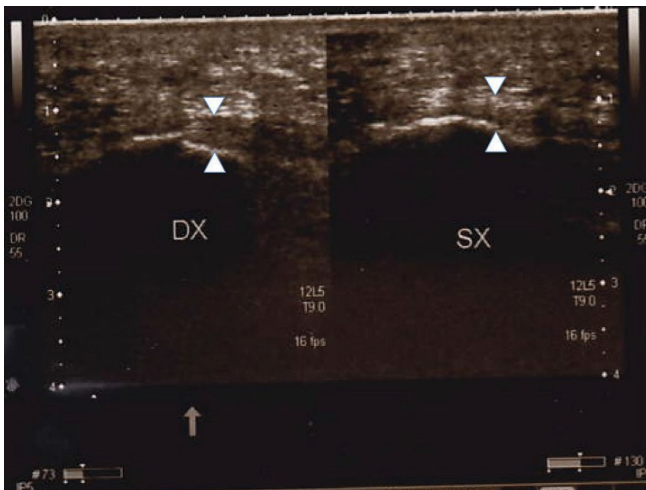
Follow-up ultrasound scan after 20 days, clinical case 2: Normalisation of the ultrasound findings for the calcaneal insertion of the right plantar fascia.
